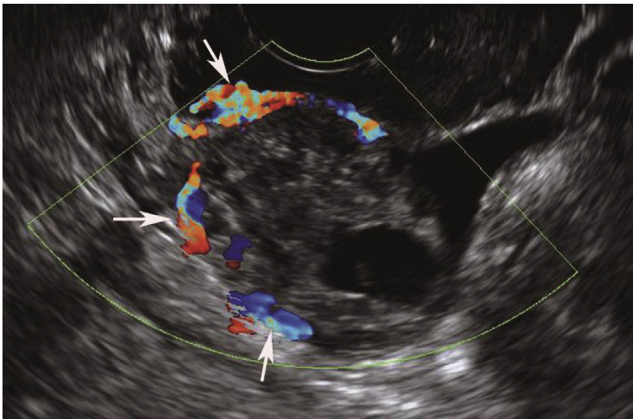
Transvaginal sonography reveals a cul-de-sac ectopic pregnancy surrounded by enormous blood vessels (arrows).
